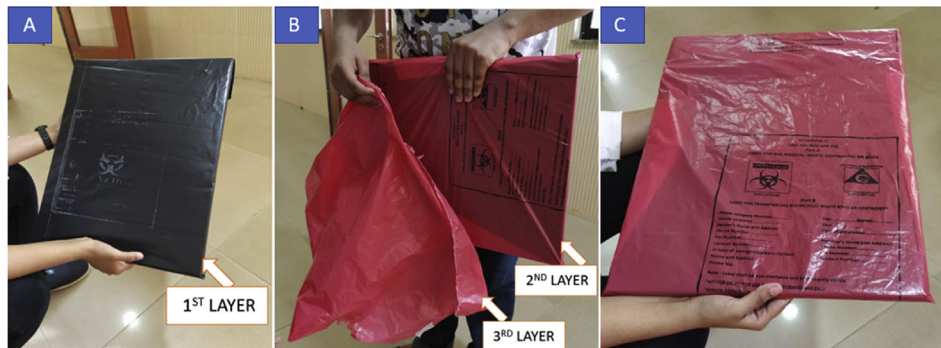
A,B,C - Three layer polythene sheet covering of the radiography cassette sealed with adhesive tapes.
